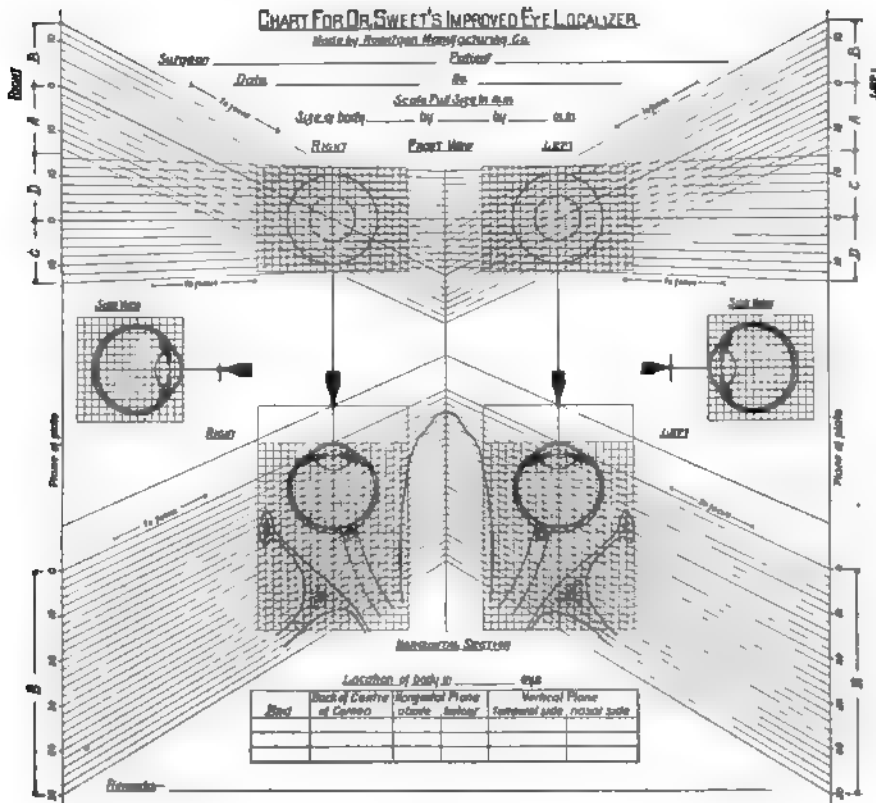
Localization chart, with lines representing course of the x-rays one-half actual size. (Sweet.)
